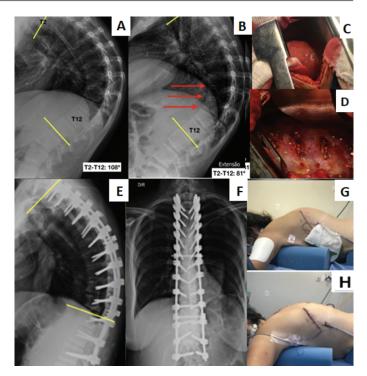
A – Preoperative X-ray of the thoracic spine from T2 to T12 showing a curvature of 108°. B – Residual curvature of 81° after dynamic testing. C – Intraoperative image of the thoracotomy. D – Intraoperative image after vertebral fusion release from T9 to T11. E – Postoperative lateral X-ray showing correction of the T2-T12 curvature to 64°. F – Postoperative anteroposterior X-ray showing spinal fusion from T2 to T12. G – Lateral image of the patient after anterior release of the T9 to T11 vertebrae. H – Lateral image of the patient after posterior spinal fusion, demonstrating significant correction of the kyphosis.
